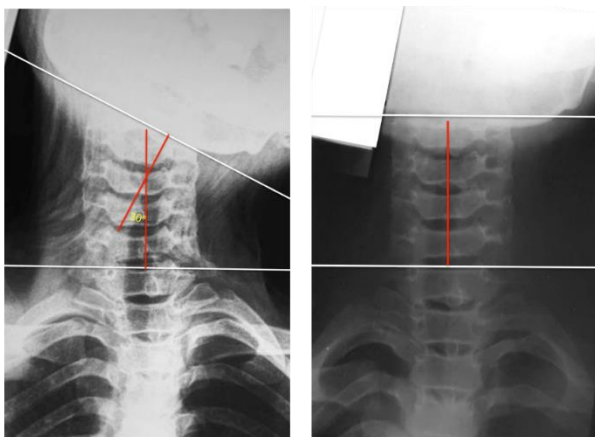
Radiographic evaluation during the preoperative and 4-months postoperative period
